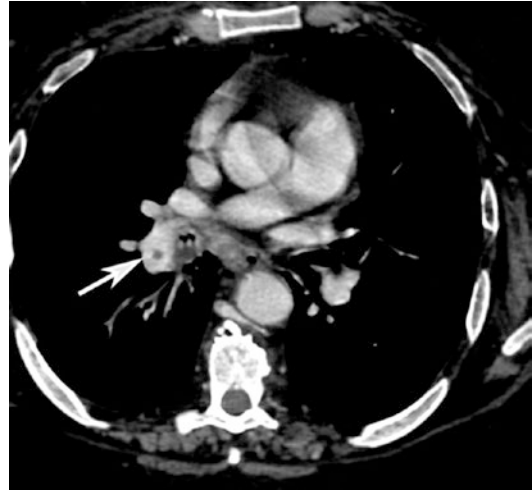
Post-contrast CT axial scan of the chest shows a small defect filling corresponding to an embolus (*arrow-head*) inside the lumen of the right lower interlobar pulmonary artery
